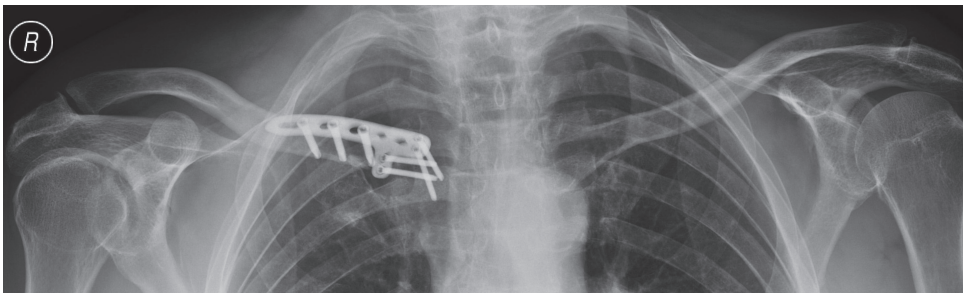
Follow up x-ray 6 weeks post-operative
